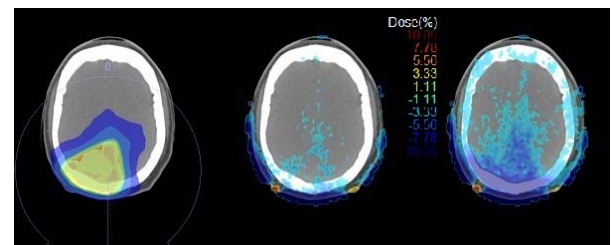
Left, dose distribution calculated using CT ED. Centre, subtraction of CT dose minus sCT dose. Right, subtraction of CT dose minus homogeneous ED dose.
